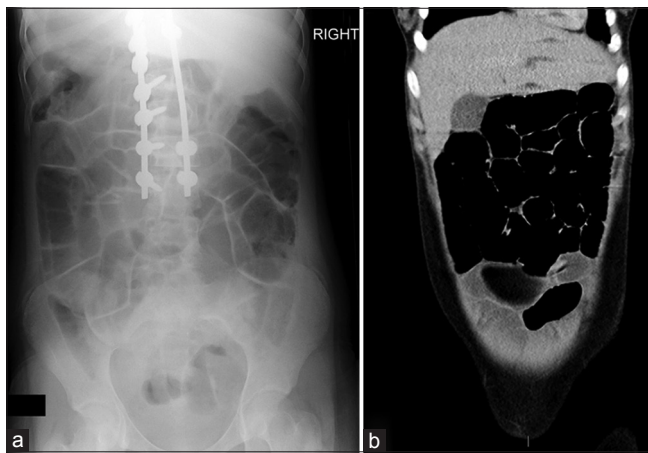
(a) Abdominal x-ray at 2 weeks after scoliosis surgery showing dilated bowel loops across the whole of the abdomen with a similar appearance on the CT scan (b) performed before decision was made for surgical exploration through a laparotomy
